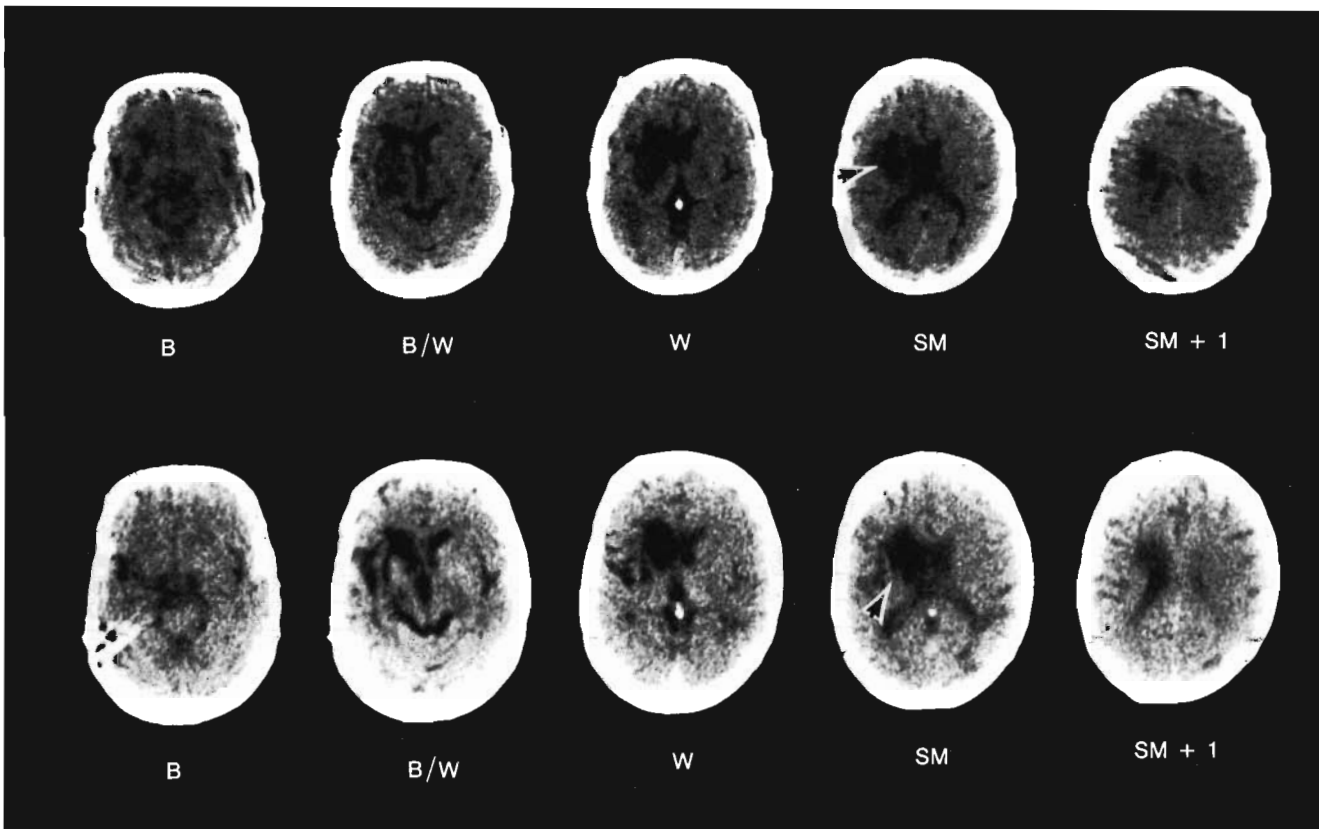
Computed tomographic scans (case 1) done one day after stroke (top) and 13 months after stroke (bottom). Subcortical lesion site with occlusive-vascular etiology is capsular putaminal with anterior-superior lesion extension. Large lesion at slice SM extends laterally from ventricle, at least halfway toward cortex (arrows).
